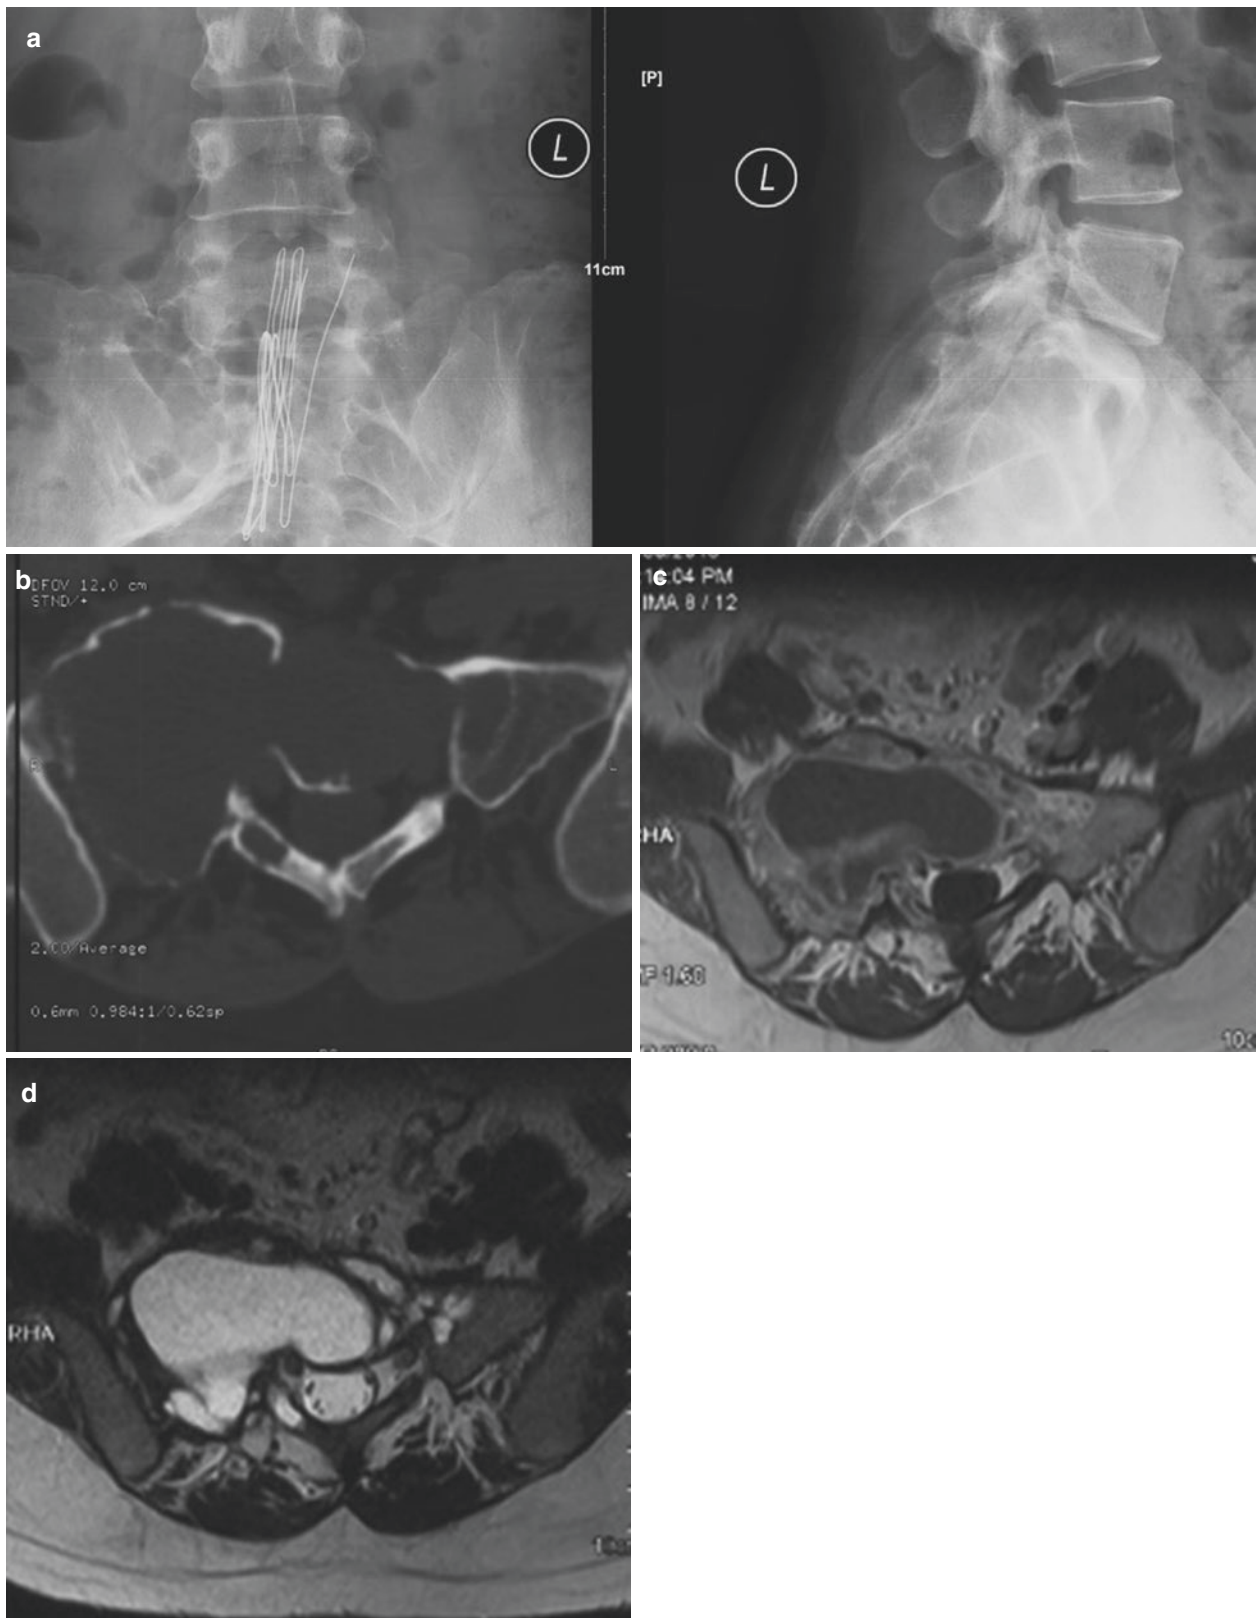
Imaging studies obtained in a 36-year-old woman with GCT of the sacrum. (a) Anteroposterior-lateral radiograph revealing a lytic destructive lesion involving S1–3. (b) Axial CT scan confirming the lytic nature of the lesion. In a patient of this age, a diagnosis of GCT should be strongly considered. Magnetic resonance imaging is very
